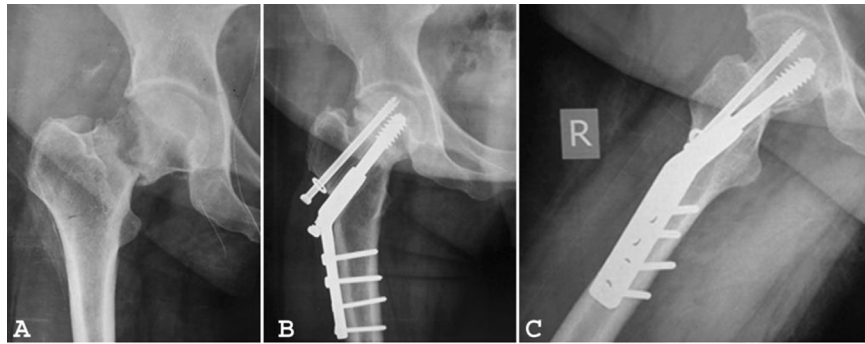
A: Preoperative radiograph of a patient showing a transcervical neck fracture. B: Anteroposterior radiograph at 1 year after fixation with sliding hip screw along with a derotation screw showing union. C: Lateral radiograph at 1 year after fixation with sliding hip screw along with a derotation screw showing union.
